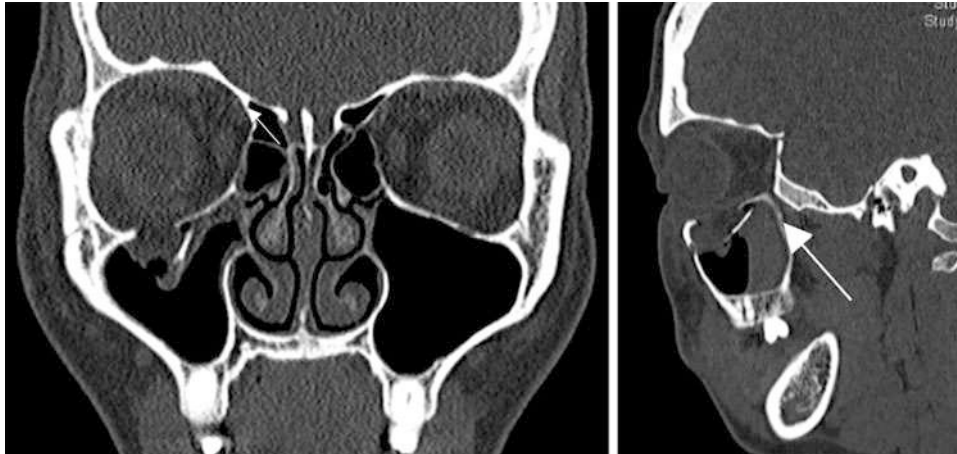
CT scan, coronal and sagittal bone windows: Right orbital floor blow-out fracture, the posterior ledge (arrow), with orbital soft tissue herniation and blood in the maxillary sinus
